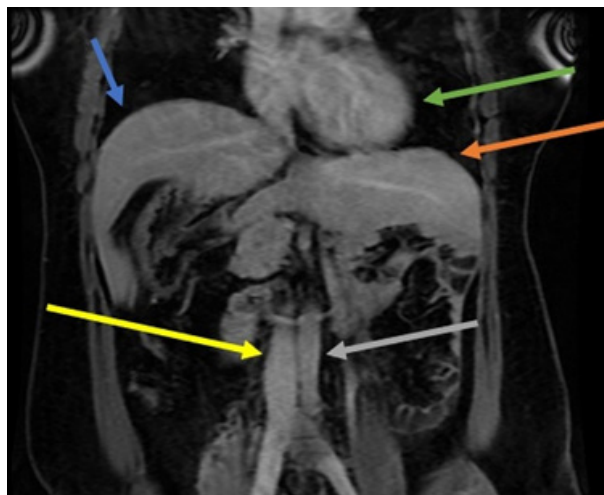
MRI in the coronal section of the T1 FAT SAT sequence with contrast showing right hepatic lobe (blue arrow), left hepatic lobe (orange arrow), aorta (gray arrow), inferior vena cava (yellow arrow), and left heart ventricle (green arrow).
